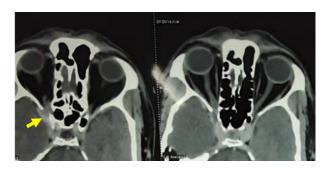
Contrast CT brain showing evidence of contrast enhancing soft tissue density lesion in orbital apex shown by arrow.
